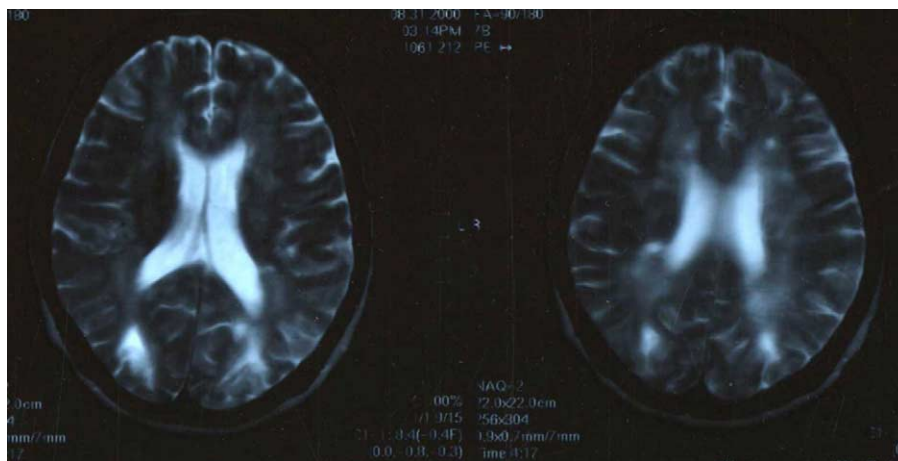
MRI scan 2 months post onset (left brain on right side). Bilateral lesions visualized in the occipito-parietal cortex.
